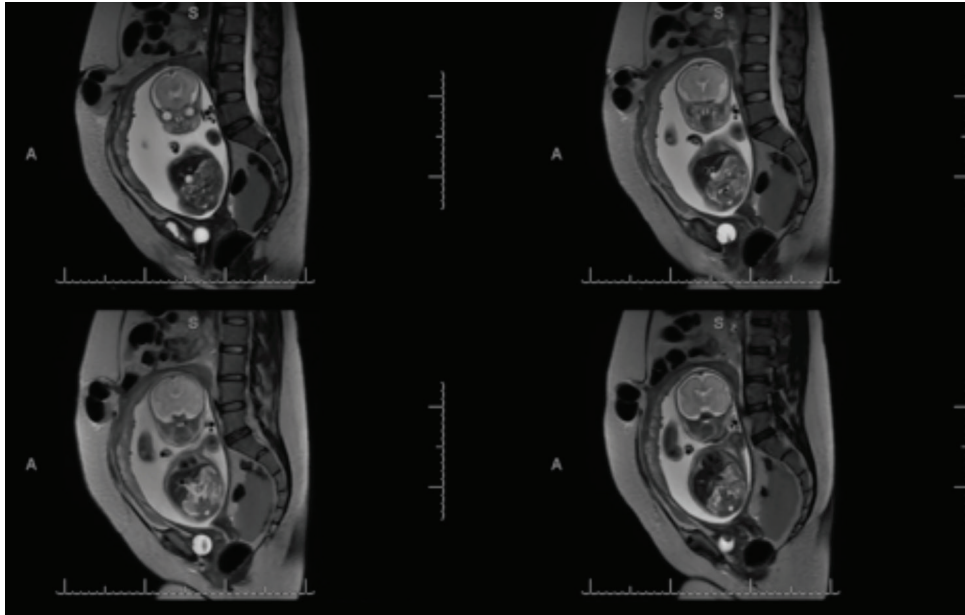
Non-contrast sagittal magnetic resonance imaging of the abdomen and pelvis demonstrating hemoperitoneum, ruptured hemorrhagic ovarian cyst, and umbilical hernia
